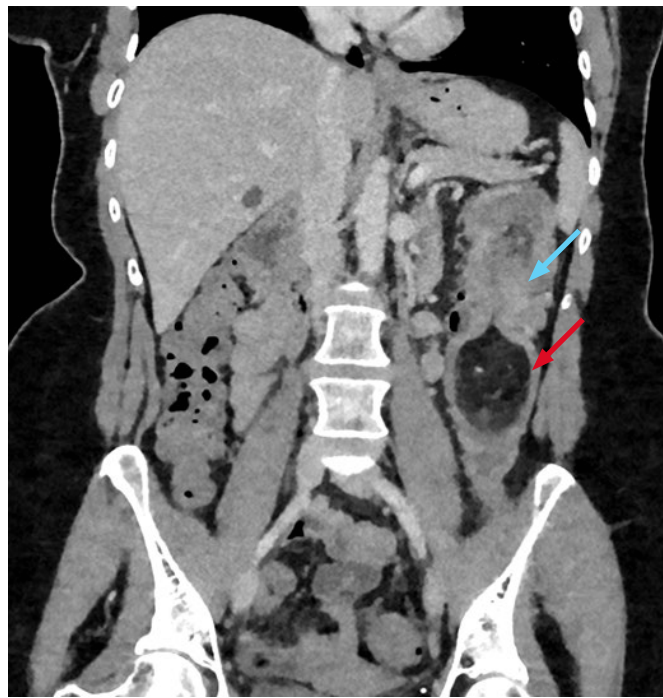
Coronal section of contrast enhanced abdominal CT showing intussusception (blue arrow) into the descending colon with lipoma as lead point (red arrow).
